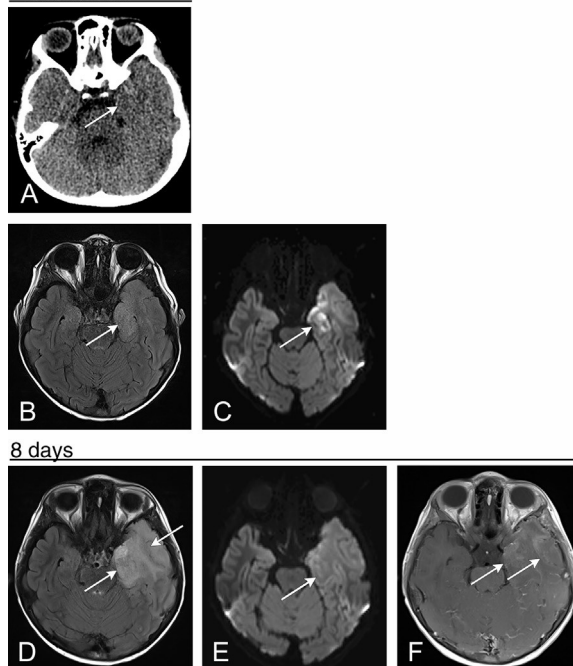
Herpes simplex encephalitis with masslike appearance. (A) Noncontrast CT in this 15-year-old immunocompromised patient presenting with encephalopathy shows no abnormality in the left temporal lobe. (B) A FLAIR image performed the same day shows increased signal in the medial left temporal lobe. (C) DWI shows foci of restricted diffusion in the left temporal lobe. (D to F) Follow-up MRI 8 days later shows markedly increased FLAIR hyperintensity (D), with resolution of previously seen restricted diffusion (E). There is associated gyriform cortical enhancement on the postcontrast T1-weighted image (F), typical of herpes simplex virus encephalitis.
